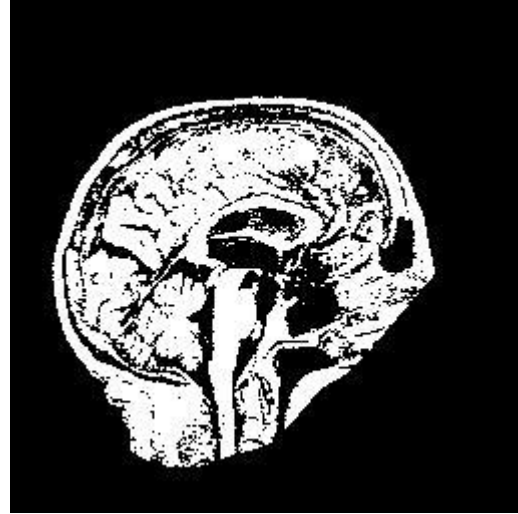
A representative MR image after denoising and Otsu Thresholding
